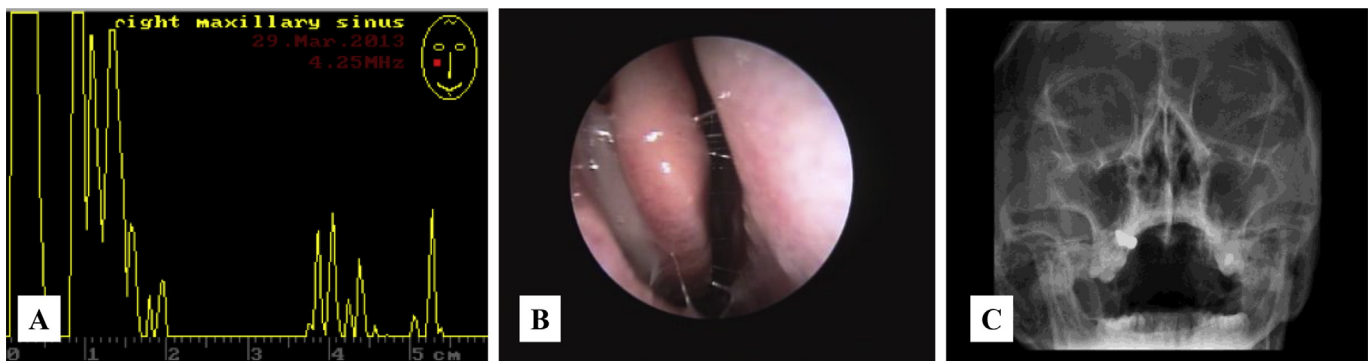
A 74-year-old female had symptoms of rhinosinusitis lasting about 1 week. (A) Sinus ultrasound detected fluid in right maxillary sinus, (B) rigid nasal endoscopy showed mucopus from right middle meatus, but (C) plain film had no evidence of right maxillary sinusitis.
